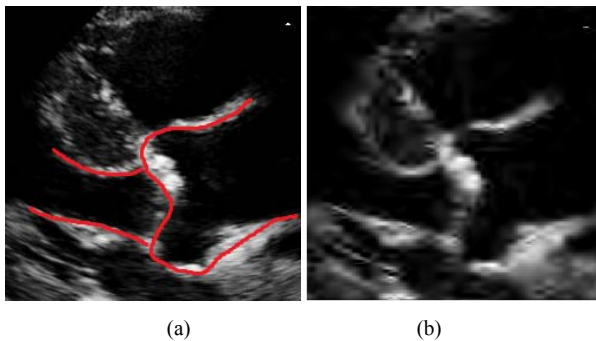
Echocardiographic of (a) raw image and (b) denoised image
